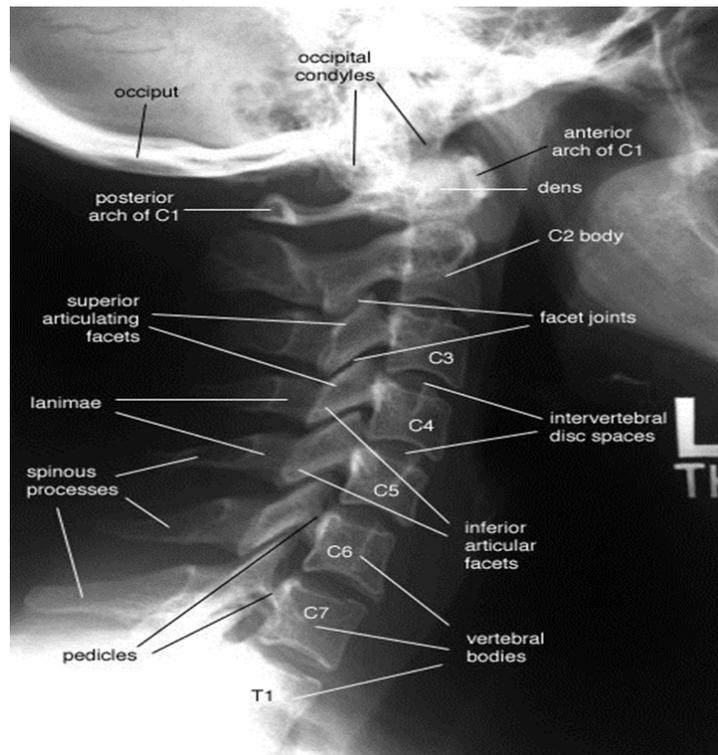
Radiograph depicting the cervical vertebrae anatomy¹²⁰
